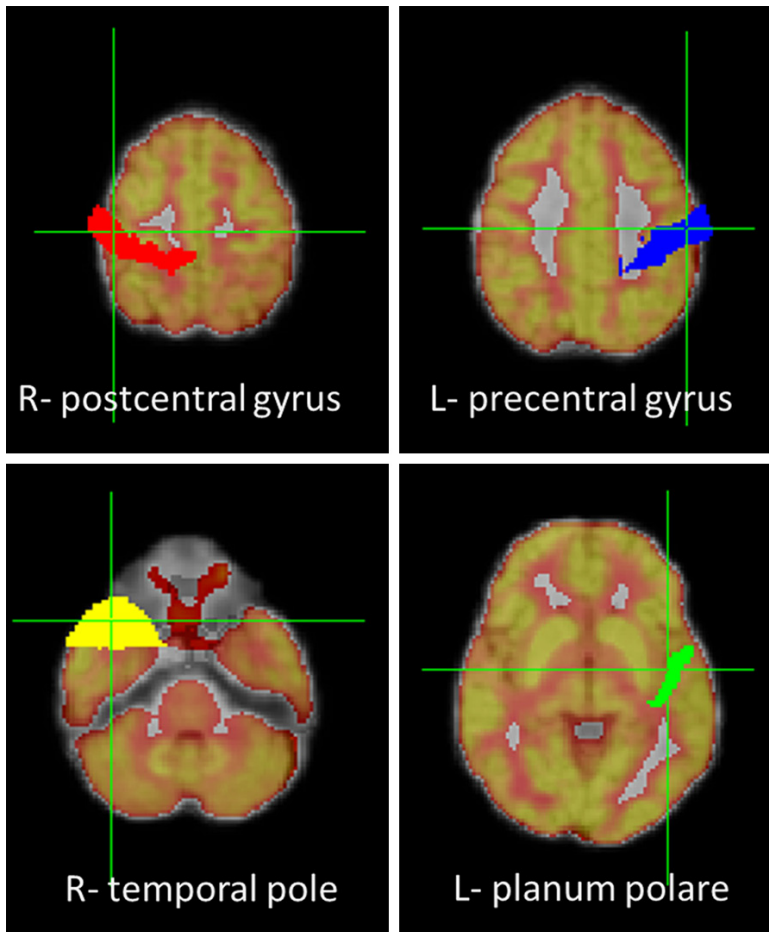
On the FDG-PET and MRI co-registered images, the upper row depicts the masks of right postcentral (red) and left precentral gyri (blue) that show hypermetabolism in epilepsy patients. The lower row depicts the masks of right temporal pole (yellow) and left planum polare (green) that show hypometabolism in epilepsy patients.
